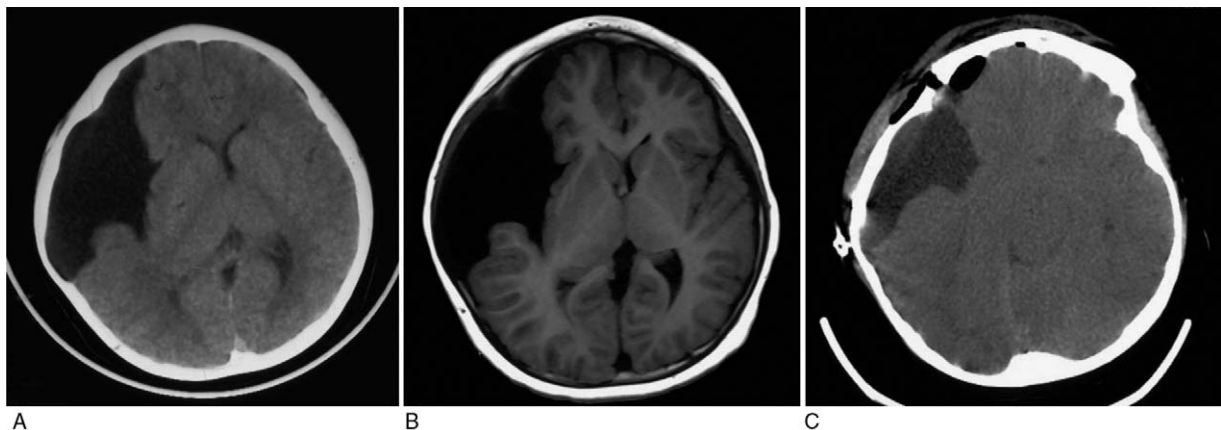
Radiological examination of the proband's cousin. Preoperative CT (A) and T1-weighted MRI (B) show an arachnoid cyst in the right anterior and middle cranial fossa. When discharged, a repeated CT shows that the size of the cyst was significantly reduced (C). CT = computed tomography, MRI = magnetic resonance imaging.
